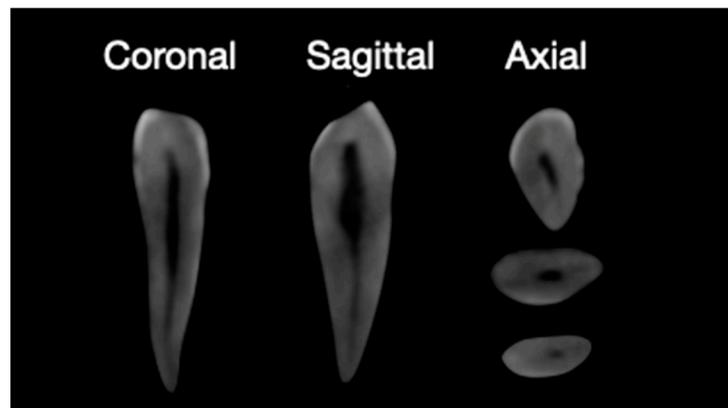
Cone beam computed tomography (CBCT) evaluation of the extracted teeth.
